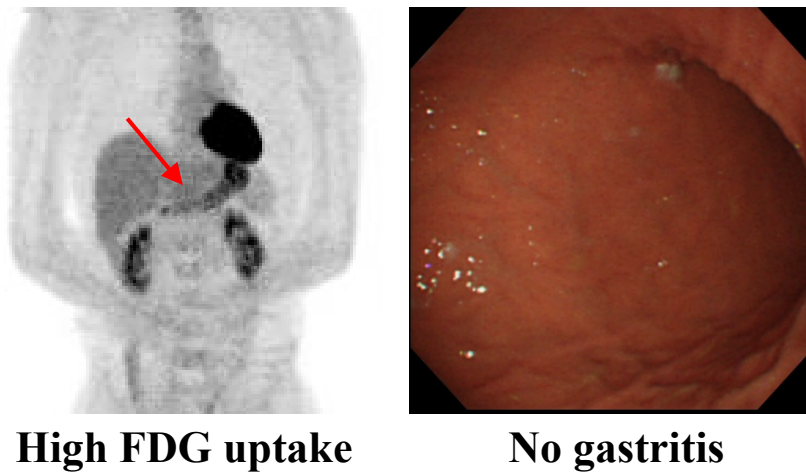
PET images of a 43-year-old man. High FDG uptake in the entire stomach was observed, but gastritis was not observed.
